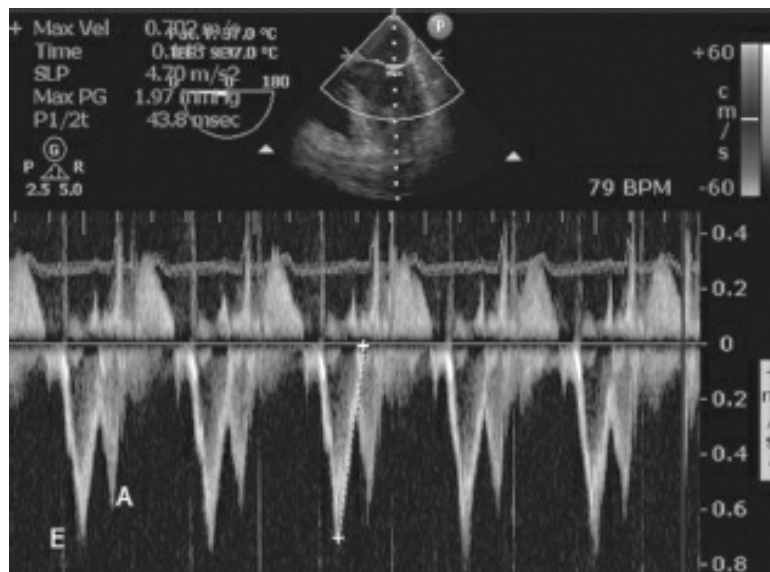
Pulsed wave Doppler flow velocity across the normal mitral valve in mid-oesophageal 4-chamber view. (E: early filling. A: late filling due to atrial contraction).
